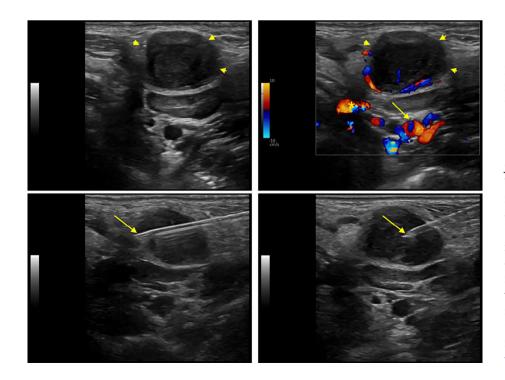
Ultrasound-guided intranodal injection. Top left: Grey scale ultrasound of a jugular lymph node with the needle (arrow heads). Top right: Color Doppler mode clearly displaying the carotid bifurcation (arrow) and the jugular vein (*). Bottom left: Needle has been inserted in an axis that avoids inadvertent puncture of any vessels. Tip of the needle (arrow) has been inserted to the deep part of the lymph node for a first location of injection in the deep and central part of the lymph node. Bottom right: Needle tip (arrow) has been withdrawn to the center of the lymph node for a second location of injection in the deep and central part of the lymph node. [Color figure can be viewed at wileyonlinelibrary.com]
